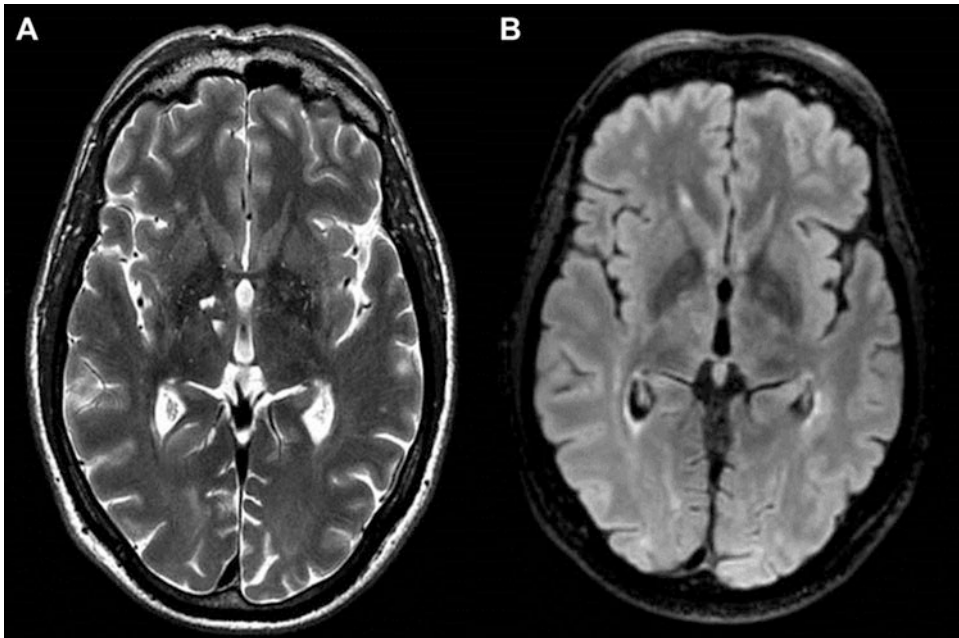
Lacunes in right thalamus on axial T2w (a), barely visible on T2 FLAIR (b)
